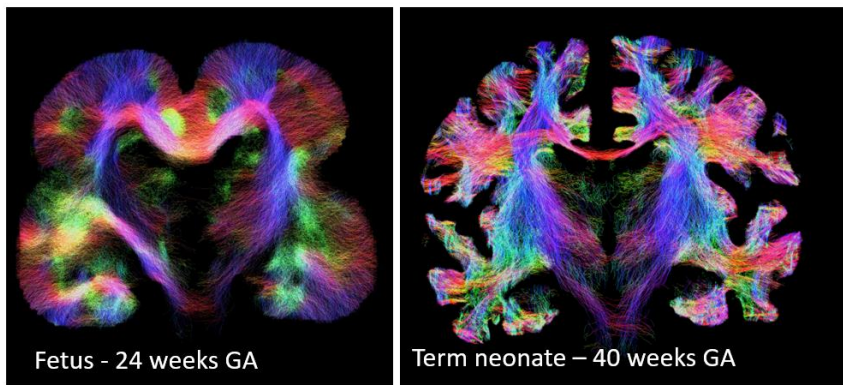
Developing brain connectivity revealed by diffusion MRI
